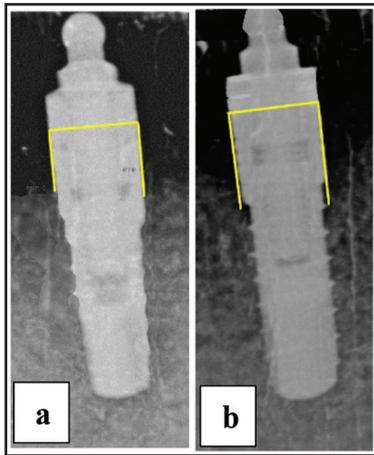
Radiographic evaluation: a-immediate loading after 9 months b-delayed loading after 9 months
